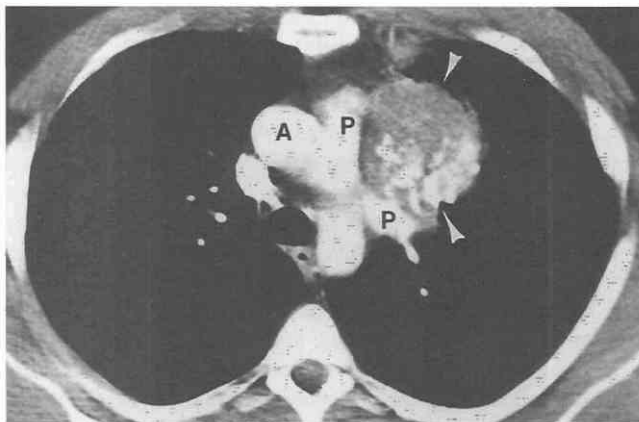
Osteosarcoma metastasis to the anterior mediastinum. Contrast-enhanced CT shows a soft-tissue-attenuation mass with extensive osteoid (arrowheads) in the anterior mediastinum. A, aorta; P, pulmonary artery.
